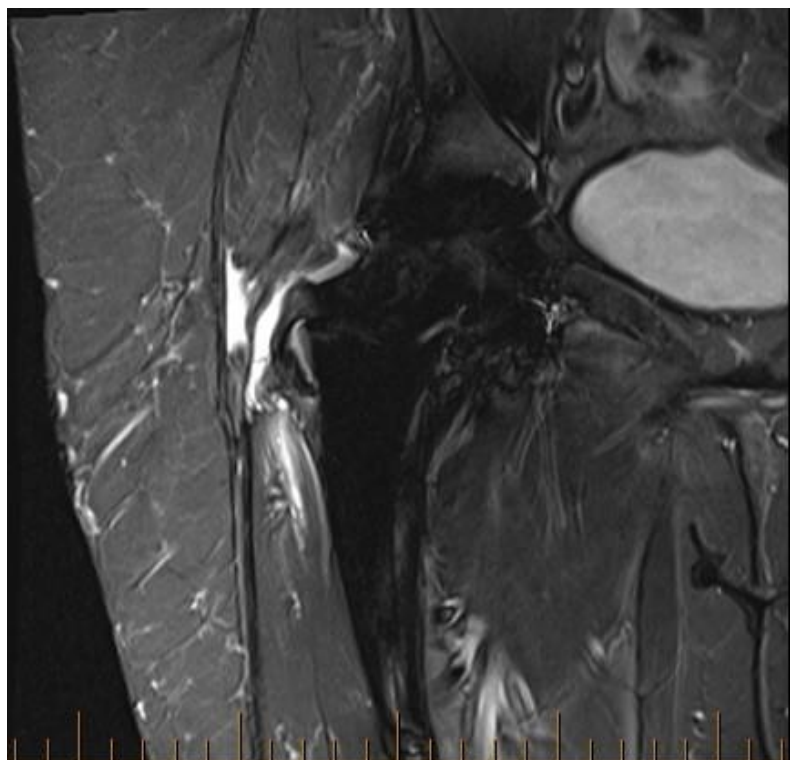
MRI hip 2016 pre-operative
